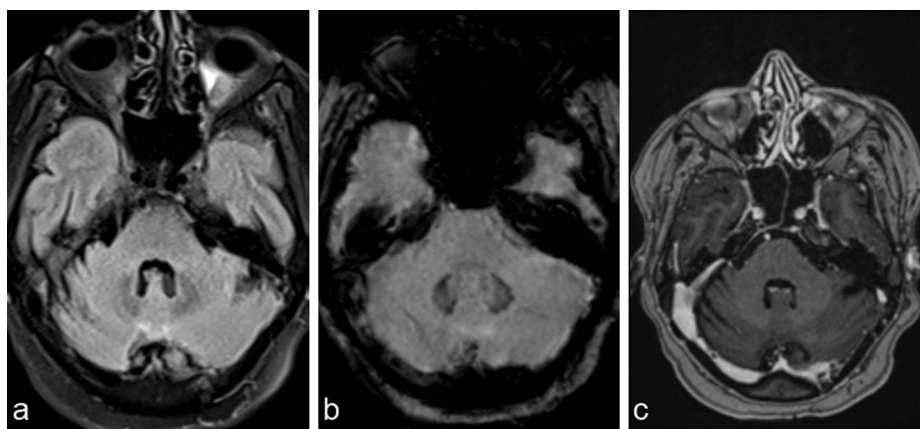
Brain MRI with contrast. (a) Axial FLAIR - cerebellar atrophy. (b) Axial SWI - susceptibility artifact related to iron deposition in the median parts of the cerebellar hemispheres. (c) Sag T1-weighted + C - without cerebellar or dural enhancement.
